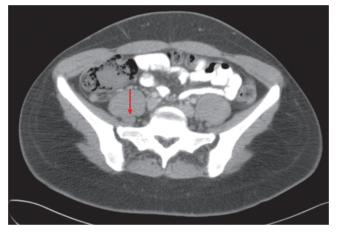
CT of abdomen in appendicitis. (Reproduced with permission from USMLE-Rx.com.)
